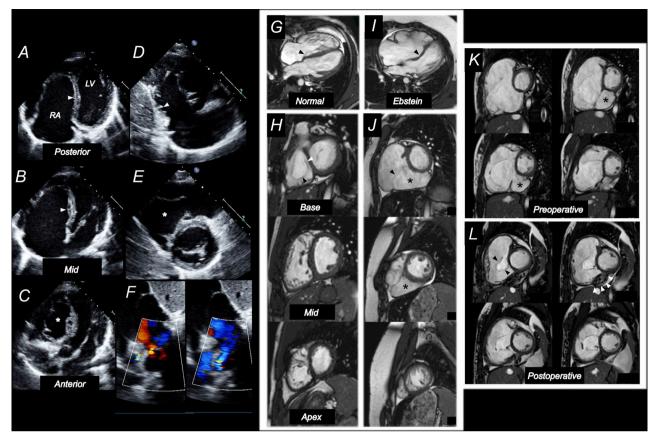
Echocardiogram (A-F) and cardiovascular magnetic resonance (G-L) images of Ebstein anomaly. (A) Apical fourchamber view tilted posteriorly, demonstrates severe tethering of the posterior leaflet of the tricuspid valve (arrow) with atrialization of the right ventricle; (B) apical four-chamber view at the midventricular level demonstrates severe tethering of the septal leaflet (arrow); and (C) apical four-chamber view tilted anteriorly demonstrates an en face view of the tricuspid valve, which is oriented toward the right ventricular outflow tract (\*); (D) parasternal long axis view tilted toward the right ventricle demonstrates severe tethering of the posterior leaflet (arrow); (E) parasternal short axis view demonstrates atrialization of the right ventricle (\*) with rotation of the tricuspid valve orifice toward the right ventricular outflow tract; (F) subxiphoid color Doppler imaging of the atrial septum demonstrates bidirectional flow through a patent foramen ovale; (G) CMR of a normal heart in the four-chamber view demonstrates normal attachment of the septal leaflet of the tricuspid valve to the annulus (arrow); (H) normal heart in the short axis view at the base demonstrates the normal formation and orientation of the septal (white arrow) and posterior (black arrow) tricuspid valve leaflets at the base of the heart with inflow directed toward the apex of the heart; (I) CMR of a heart with Ebstein anomaly demonstrates tethering of the septal leaflet (arrow), and (J) an elongated anterior leaflet (arrow) with atrialization of the right ventricle (asterisk) at the basal and mid-ventricular level; (K) preoperative CMR images of a patient with Ebstein anomaly after dehiscence of a previous right ventricular plication (\*); (L) postoperative CMR images after Cone reconstruction of the tricuspid valve, resulting in a bileaflet valve (black arrows) and tissue thickening along the inferior wall of the right ventricle from a repeat plication (white arrows).
